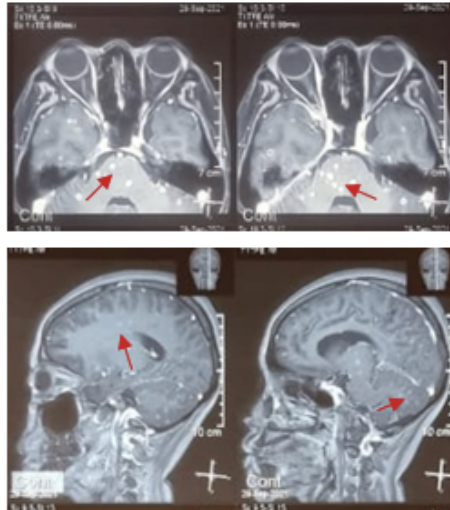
Head MRI examination result. Multiple ring enhancement was found in bilateral fronto-temporoparietooccipital lobes, bilateral centrum semiovale, right corona radiata, bilateral external capsule, bilateral thalamus, mesencephalon, pons, and cerebellum.
